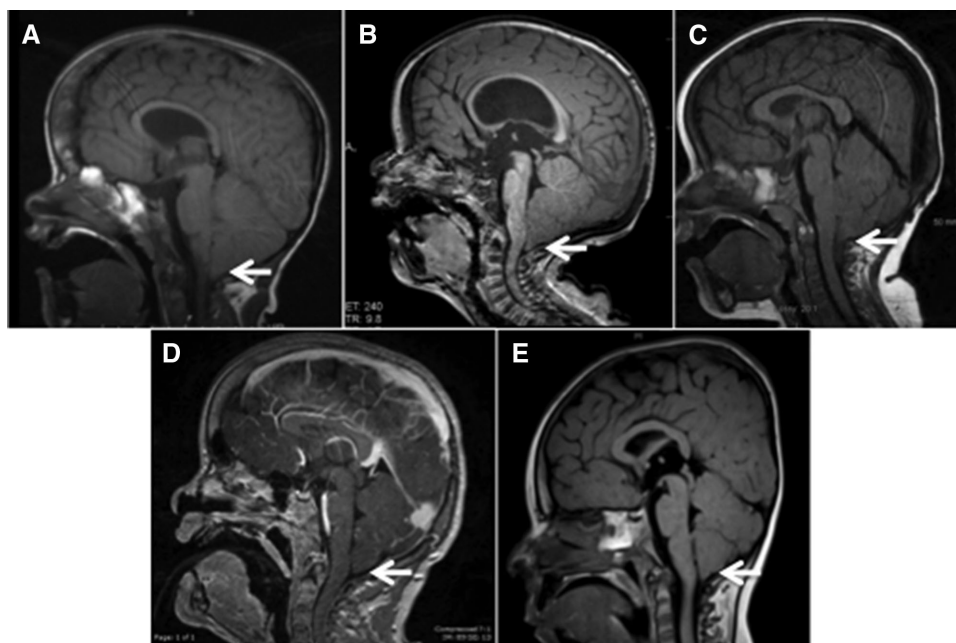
Brain MRI showing signs of Chiari type I malformation. Sagittal T1 MRI image from cases 2(A), 3(B), 5(C), 8(D), and 9(E) showing Chiari type-I malformation (arrows).
